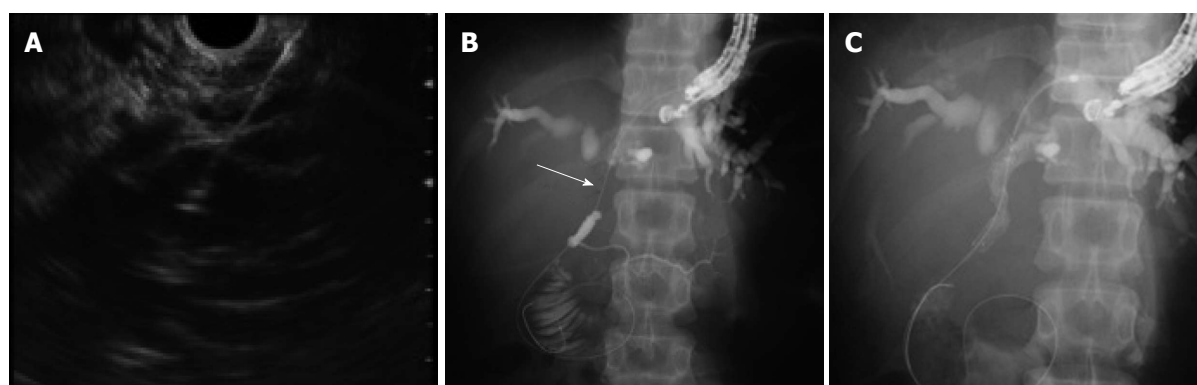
Endoscopic ultrasonography-guided antegrade treatment. A: Left intrahepatic bile duct was punctured; B: Guidewire was advanced through the needle across the stricture (arrow); C: A self-expandable metallic stent was placed antegradely across the stricture.
